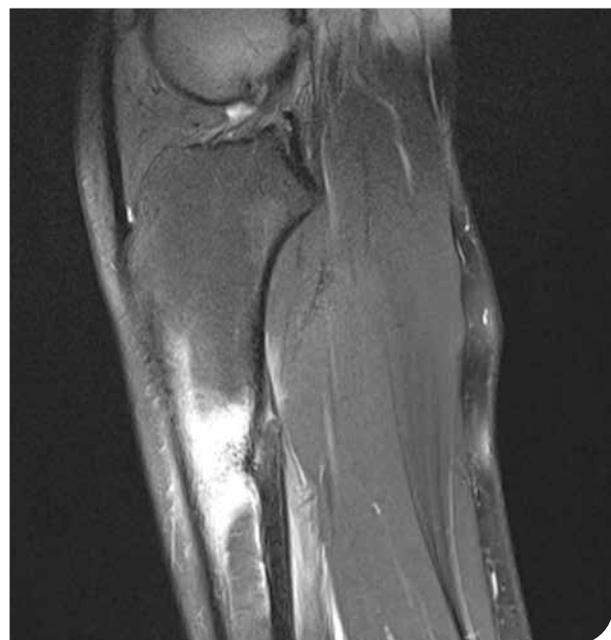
Magnetic resonance imaging (MRI) of upper tibial stress fracture
